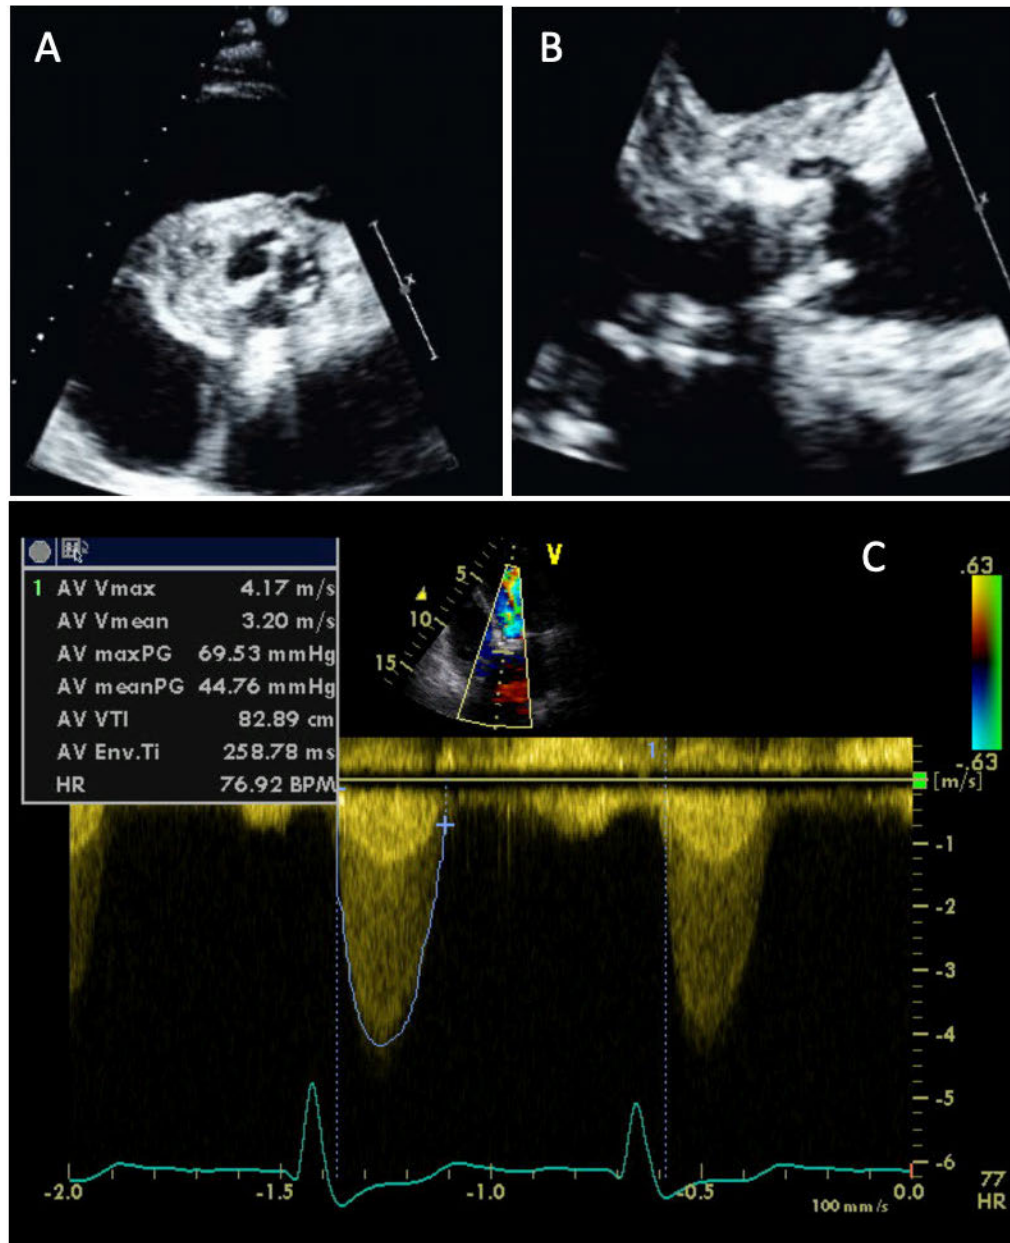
Images from a transthoracic echocardiogram of a patient with aortic stenosis showing severe fibrocalcific thickening of a trileaflet aortic valve in the parasternal short axis (A) and parasternal long axis (B), and a continuous wave Doppler profile aligned to the aortic valve in the apical 5-chamber view with measurements consistent with severe aortic stenosis (C).
